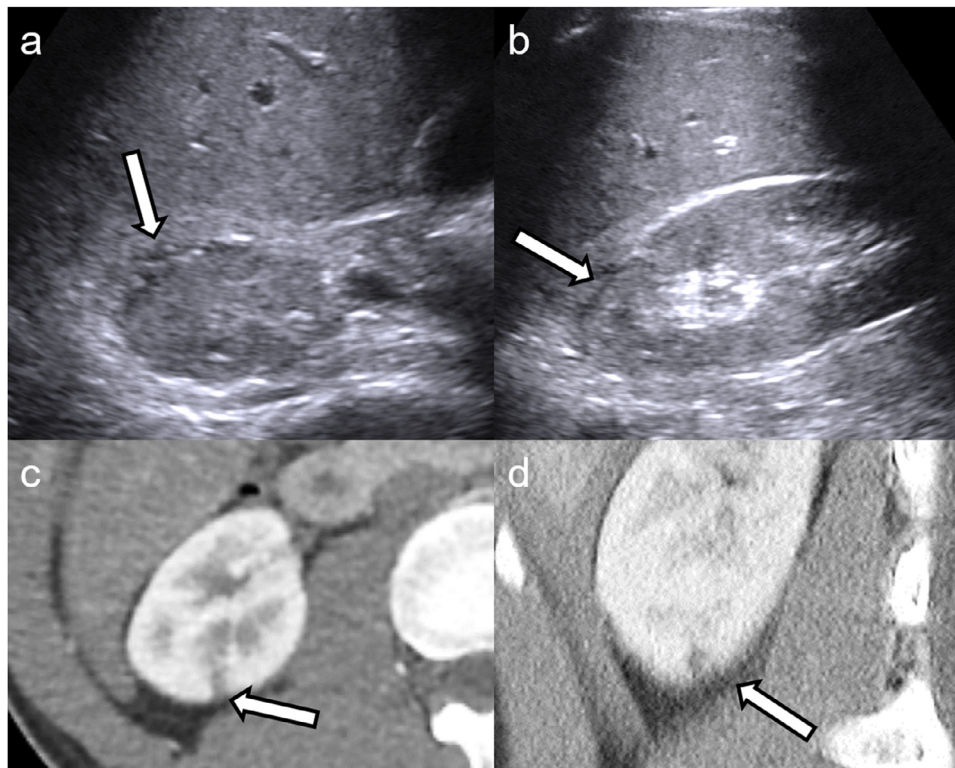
Renal ultrasound of a 17-year-old adolescent in axial (a) and coronal (b) plane on the right side. Slight subcapsular fluid is noted. Contrast-enhanced CT (axial (c), coronal (d)) revealed a grade II injury at the lower kidney pole with a depth below 1 cm diagnosed as grade II injury.
